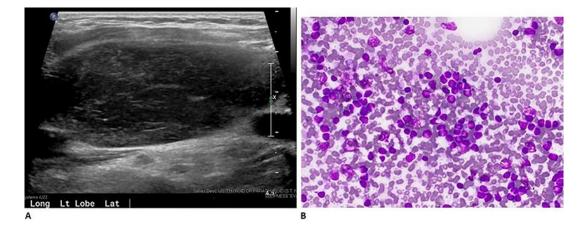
A Thyroid ultrasound showing a dominant hypervascular left thyroid mass 5.9 × 2.7 × 4.4 cm. B Fineneedle aspiration biopsy of the left dominant thyroid nodule revealing background small lymphocytes, scattered plasma cells, and neutrophils with rare, large, atypical forms with prominent nucleoli (DiffQuik).
